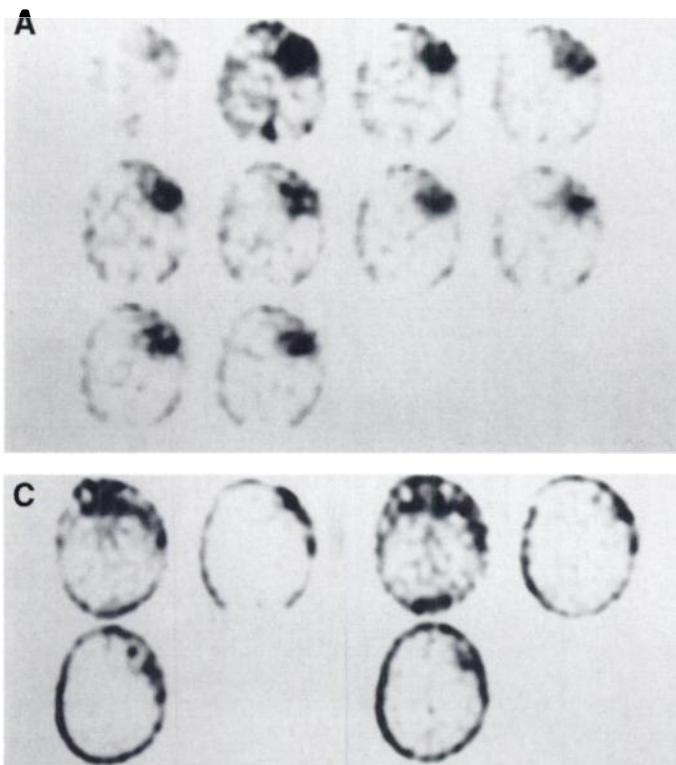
Thallium-201-Cl brain SPECT images before (A, B) and after (C) partial tumor resection. Thallium-201-Cl dynamic images (A) demonstrate increased peak accumulation in the tumor on the second frame and then gradually decreased and eccentric localization of tumor uptake. Static images show localized accumulation in the posterior and lateral portions of the tumor on the early (left) and delayed (right) images before surgery (B). There was faintly increased uptake and mild retention on the early (left) and delayed (right) images after surgery (C).
